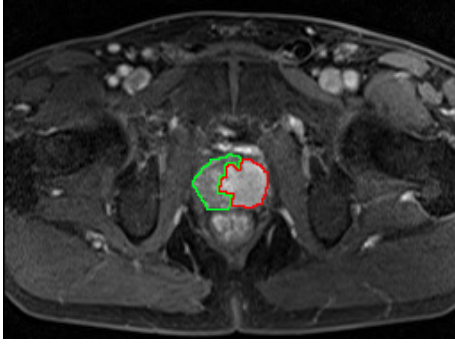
Rendering of T<sub>2</sub>-W-MRI prostate image with both 1.5 and 3.0 Tesla MRI scanner.
